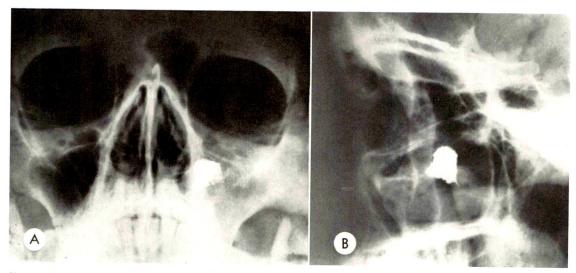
Case III. (A and B) Roentgenograms showing diffuse clouding of the left antrum containing a single conglomerate of radiopaque material apposed to the medial wall. Note polyhedral shape and irregular contour.
